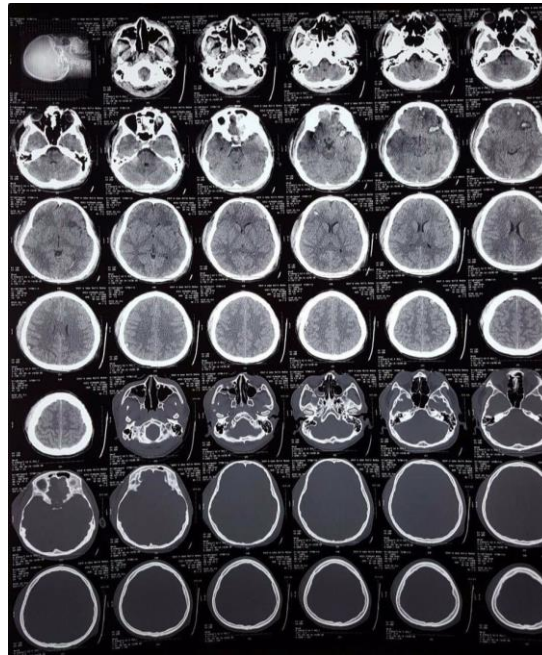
CT-Scan show contusion in the left frontal region.
